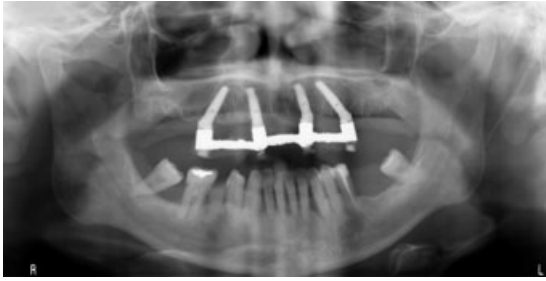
Panoramic radiograph of a patient treated with the “All-on-4” protocol. The two distal implants were placed parallel to the anterior wall of the maxillary sinus.
